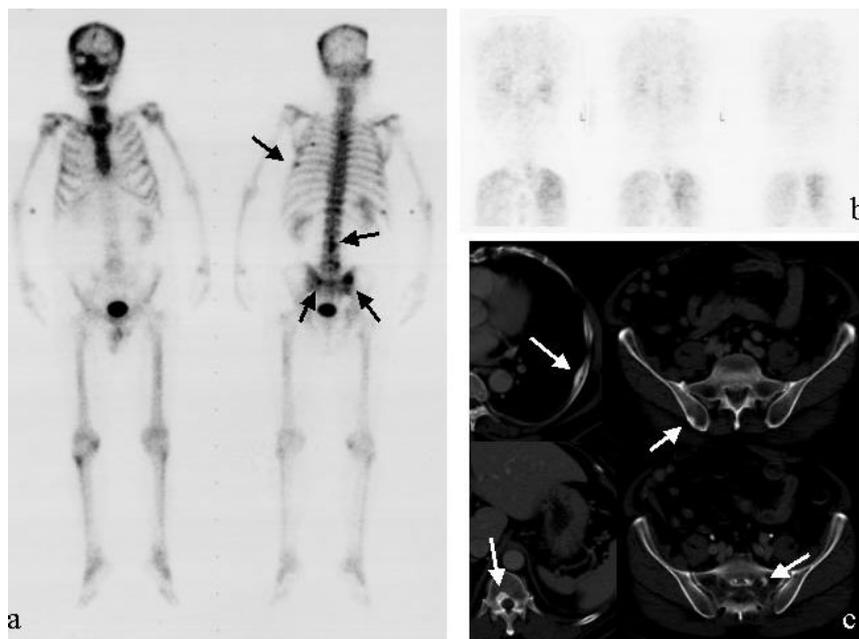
A case of chemotherapeutic effect evaluation (patient #18). Seventy-year-old male patient with prostate cancer. In the follow-up period after operation of the primary lesion, he was diagnosed as having multiple bone metastases (PET and BS showed positive before treatment), and chemotherapy was performed. BS and FDG-PET were performed to evaluate the therapeutic effect (a, b). BS showed multiple uptake in bilateral ribs, lower vertebrae, sacrum and ilium (a). FDG-PET was performed, but whole-body scan showed no uptake of FDG (b). CT scan showed multiple increased densities in the corresponding lesions (c). Clinical data supported the results of FDG-PET as therapeutic effect.
